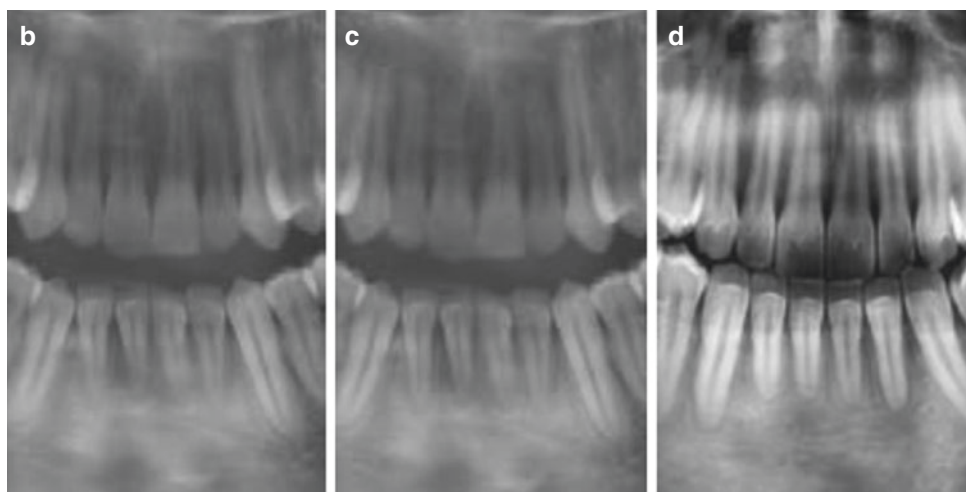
Multi-layer panoramic radiography provides up to five images at various horizontal depths with a wide focal trough with only one scan and comparable radiation dose as traditional imaging (a). The image layer which
